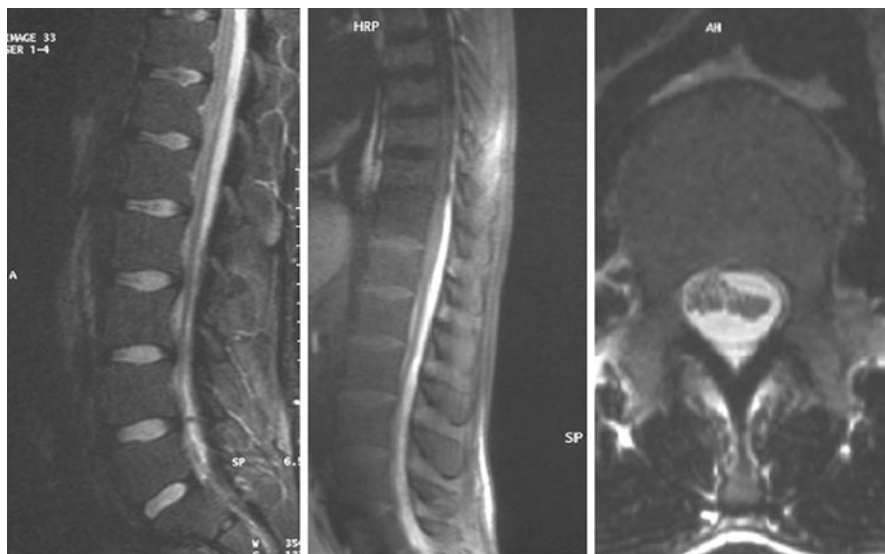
Sagittal T1- (*left panel*) and T2-weighted MRI (*middle panel*) showing a hematoma extending from T10 to S2 vertebral bodies, most prominent at L1–L3 level, and displacing laterally the lumbosacral roots and the conus medullaris (*right panel*, axial view)
